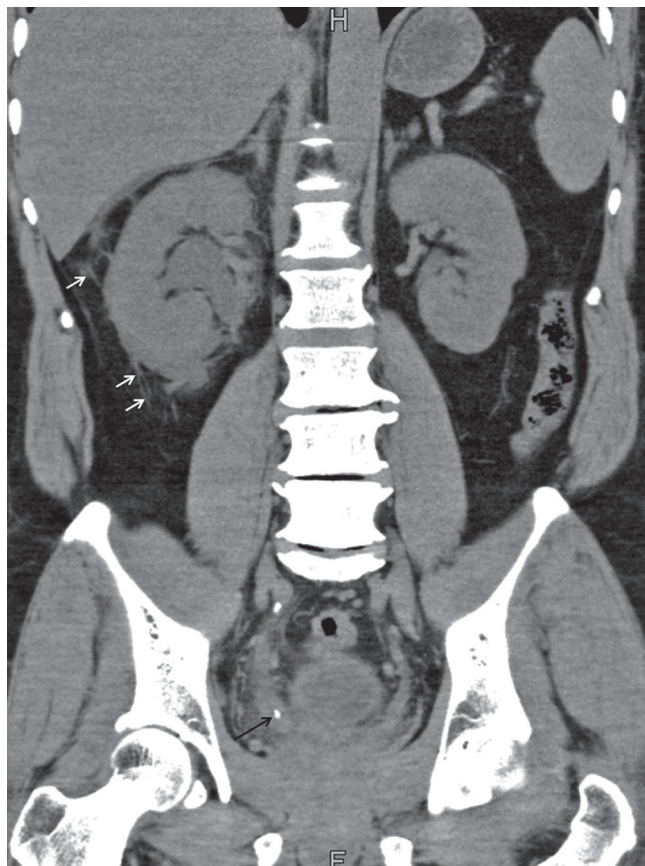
Coronal CT image from a patient with right-sided renal colic. Not only is the calculus in the right distal ureter clearly visualized (*black arrow*), the secondary signs of perinephric fat stranding (*white arrows*) are also present. In the absence of direct visualization of the calculus (the calculus either having been passed or too small to resolve), these secondary sign are extremely useful and may be used to confirm the diagnosis of renal colic as the cause of a patient's symptoms
